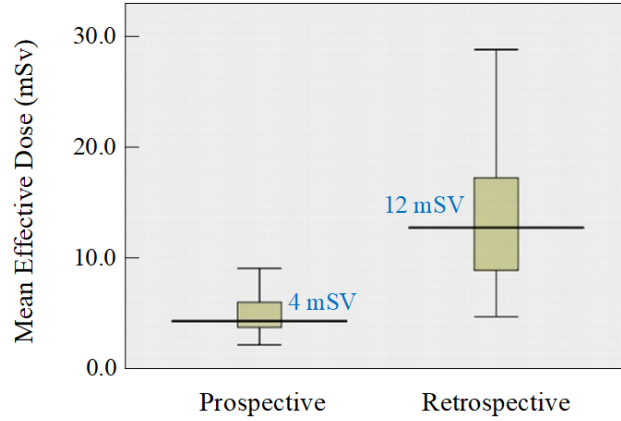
Mean effective dose associated with retrospective (12 mSv) gating and prospective triggering (4 mSv). Statistics are based on the Siemens Definition Flash dual-source 128-slice CTA scanner (Siemens, Erlangen, Germany). Horizontal line in each box shows median and top and bottom lines of boxes show interquartile range. Figure reproduced from [18].
